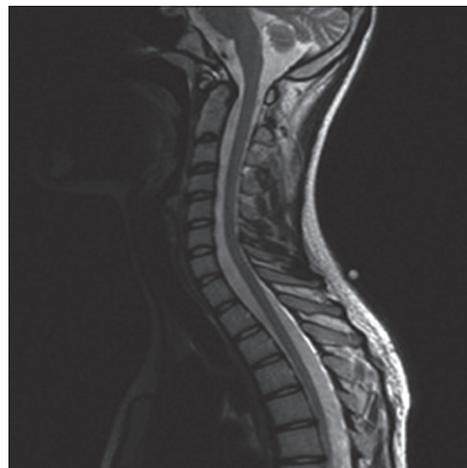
Normal MRI spine
